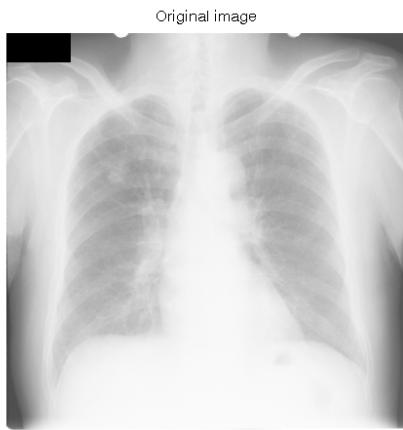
Original 2048x2048 chest radiograph image I
